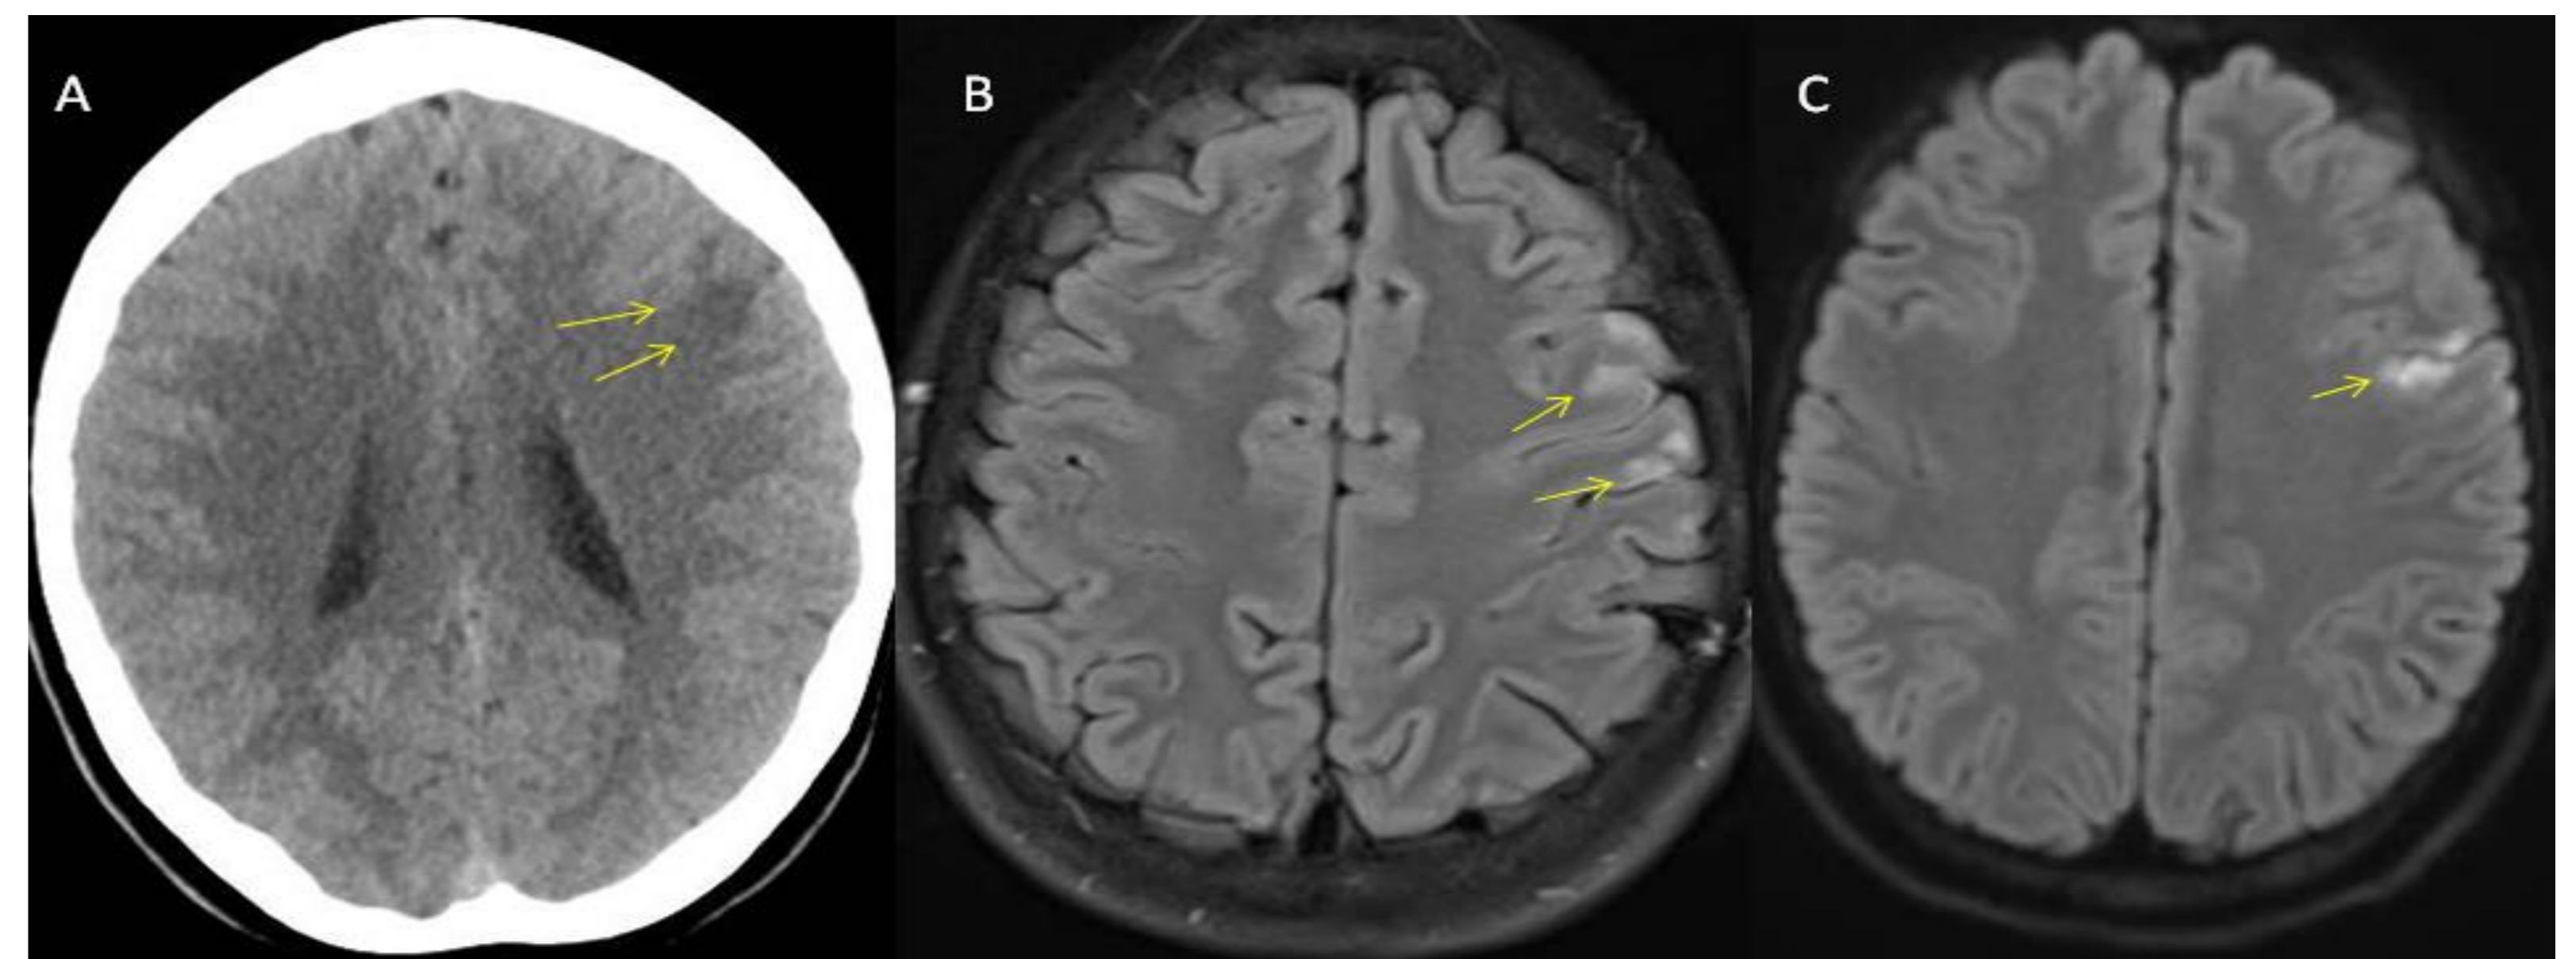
(A-C): A, uncontrasted CT brain showing hypodense lesion in the left frontal lobe. B: M brain FLAIR sequence showing high signal abnormality affecting the left middle cerebral artery territory. C: Diffusion weighted sequence showing an area of restricted diffusion of the left middle cerebral artery distribution indicating acute infarction.
